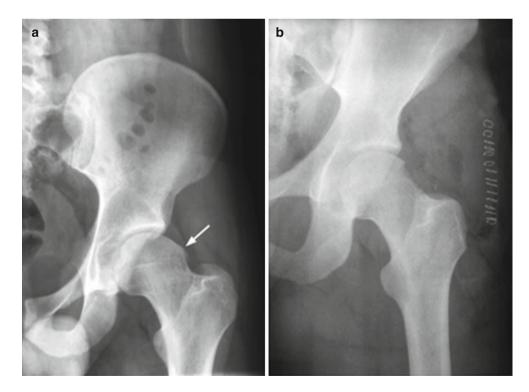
Radiographs of a 21-year-old male. These pre and postoperative images demonstrate a femoral head cam deformity that has been resected via an open approach
